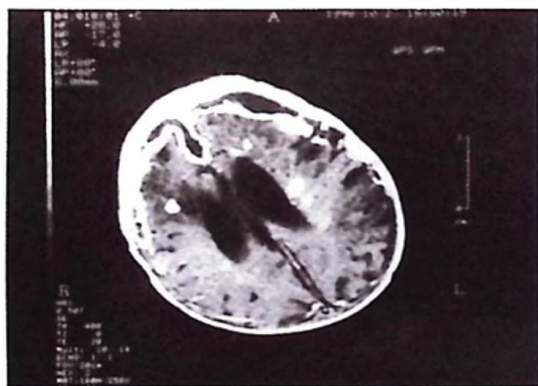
Computerized tomography (CT) scans showing multiple brain abscesses.
